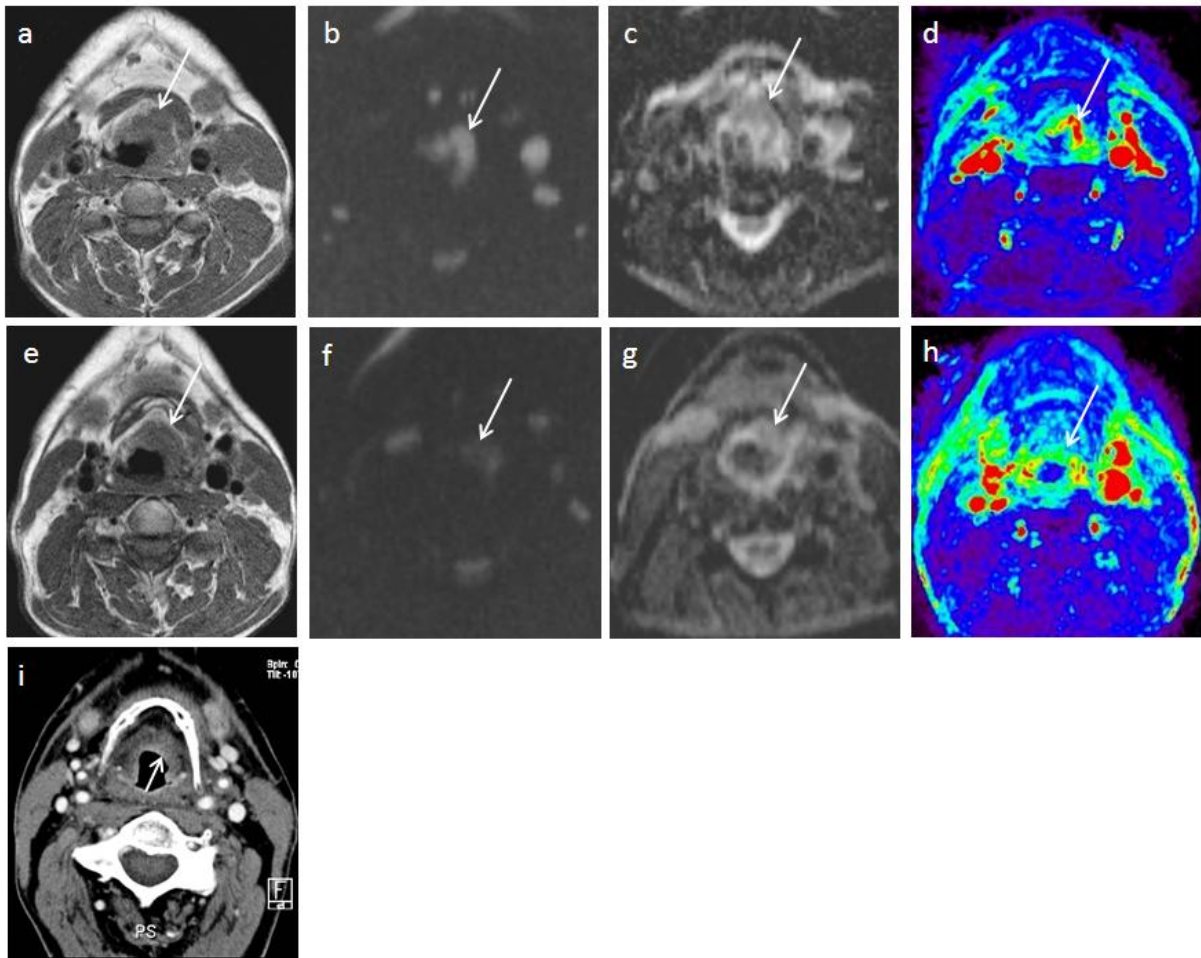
Upper row: Left supraglottic ulcerated tumoral mass on (a) contrast-enhanced T1-weighted turbo-spin echo (TSE) MRI, (b) b1000 diffusion-weighted image, (c) ADC-map and (d) arterial slope perfusion map. Middle row: (e) The supraglottic tumour shows unchanged volume at 2 weeks during chemoradiotherapy. (f) the tumour shows substantial decrease of signal intensity on the b1000 diffusion-weighted image, corresponding to (g) a ΔADC (in %) > 40 and ΔPERF (in %) > 50 . These findings are indicative of good treatment response. (i) Follow-up CT scan after 2 years shows complete remission of the primary tumour site.
